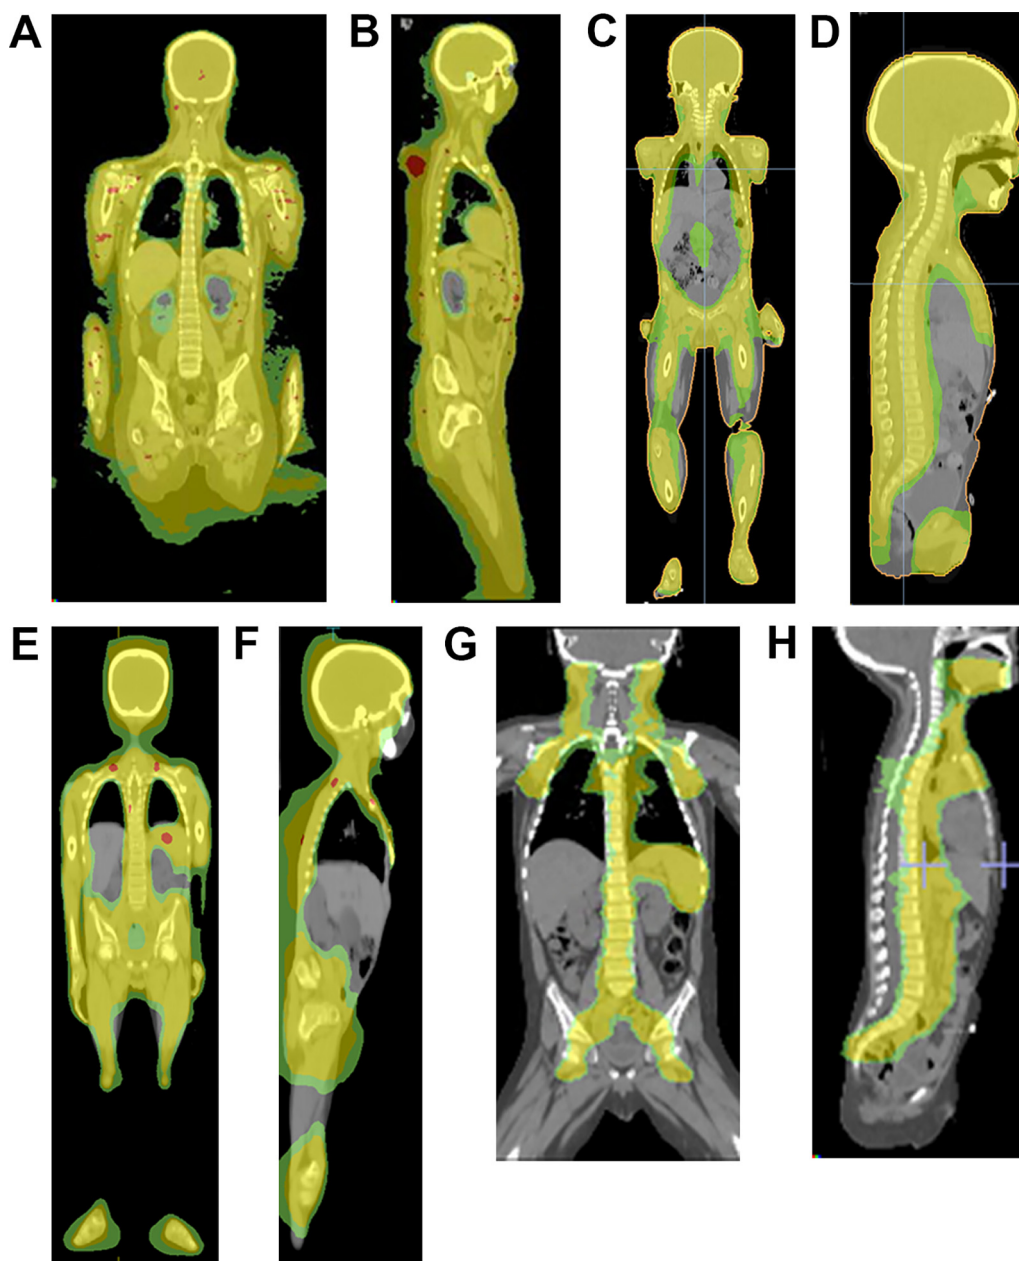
CT-planned dose distribution for highly conformal optimized techniques. Coronal (A) and sagittal (B) isofill dose distribution of VMAT TBI with dose reduction to the lenses, kidneys and lungs. Coronal (C) and sagittal (D) isofill dose distribution of Total Myeloid Irradiation (with inclusion of CNS and testes). Coronal (E) and sagittal (F) isofill dose distribution of Total Marrow and Lymphoid Irradiation (with inclusion of CNS). Coronal (G) and sagittal (H) isofill dose distribution of Total Lymphoid Irradiation. Green = 75% isodose; yellow = 90% isodose; red = 110% isodose.
